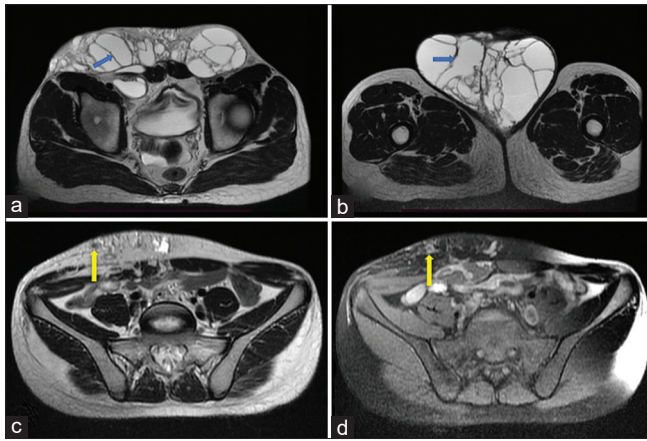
Magnetic Resonance Imaging (MRI) (a) T2 weighted image showing dilated lymphatic channels in the bilateral inguinal region, and (b) extending up to the scrotum with septae (blue arrows) within it. (c) T2 weighted and (d) T1 weighted fat sat images showing flow voids (yellow arrows) in the subcutaneous region surrounding the lymphatic channels suggestive of traversing vessels
